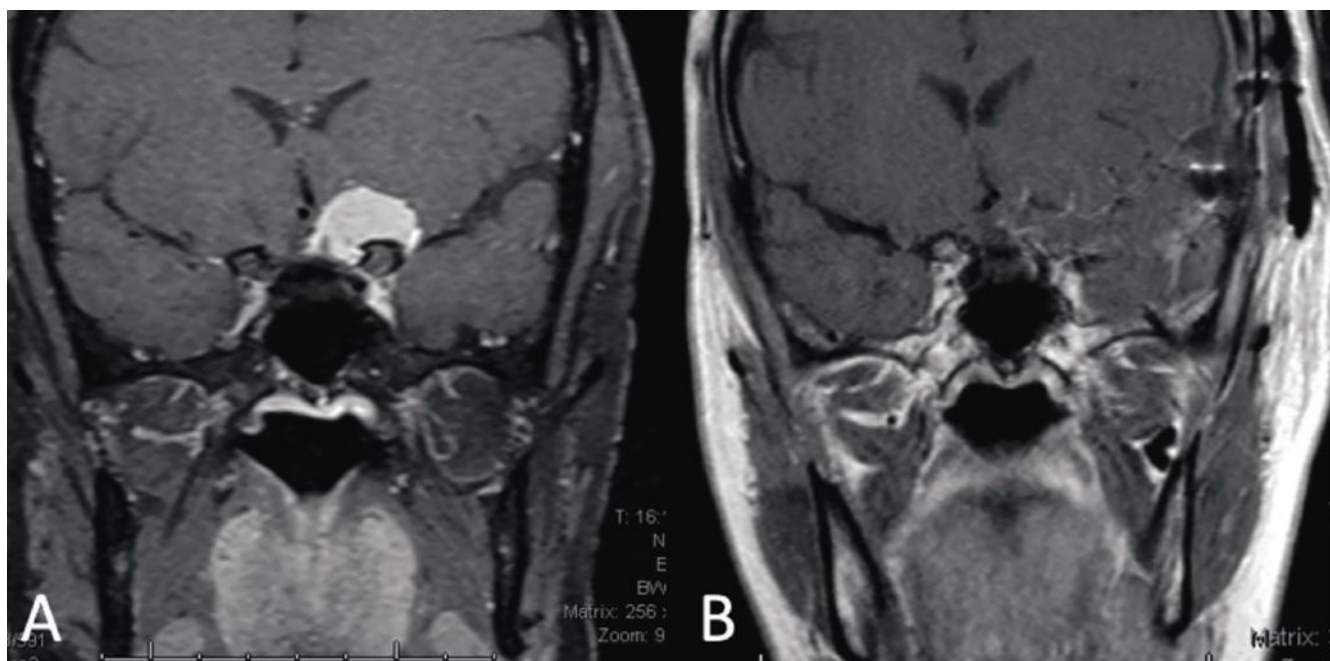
(A) Coronal MRI depicts an approximately 2cm paraclinoid meningioma exerting its mass effect on the left half of the optic chiasm and the prechiasmatic optic nerve. (B) Coronal MRI taken two weeks post-craniotomy and resection of the meningioma.
